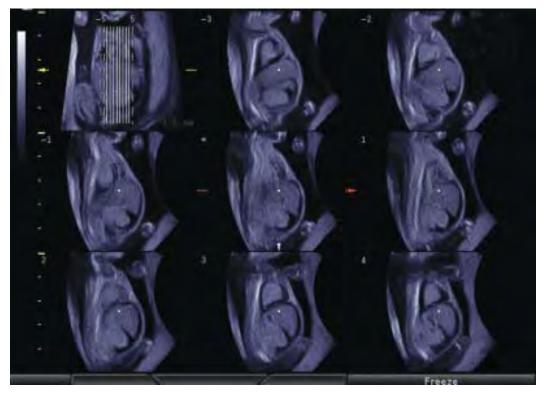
Pleural effusion and ascites at 19 weeks. Tomographic ultrasound sagittal image of the fetal trunk. Fluid collection in both chest and abdomen are clearly demonstrated
